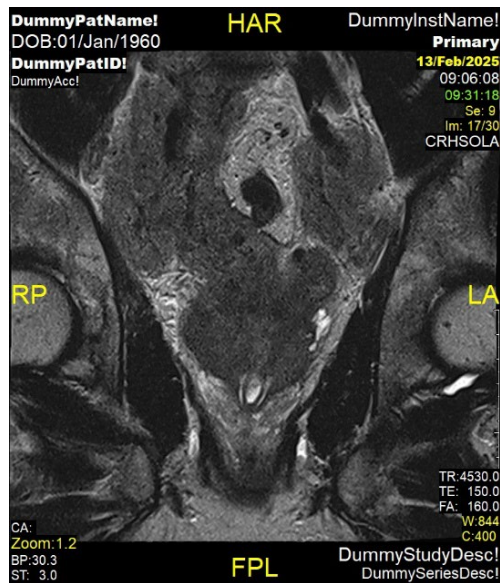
Coronal T2 MRI of pelvis showing prostate mass extending into both pelvic sidewall masses.
